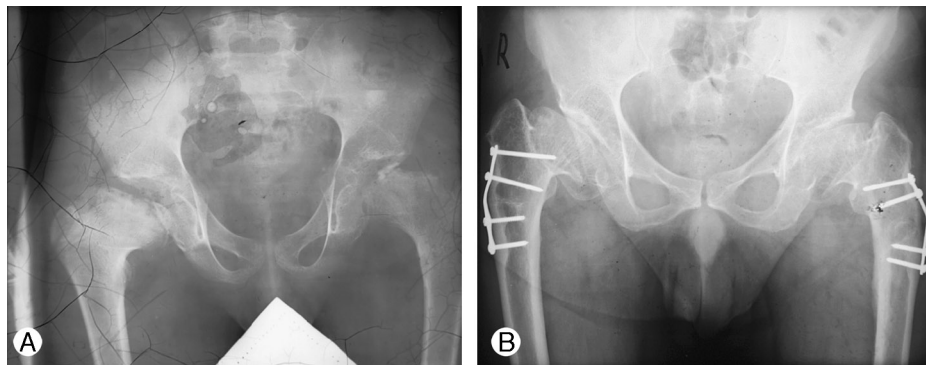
A, A preoperative AP radiograph of the pelvis of a 12-year-old boy shows bilateral LCPD with the formation of a very irregular femoral head and unsatisfactory femoral head coverage. B, A postoperative AP pelvic radiograph of the patient at age of 44 years (36 years' follow-up) demonstrates a broadened deformed head with moderate signs of osteoarthritis.
